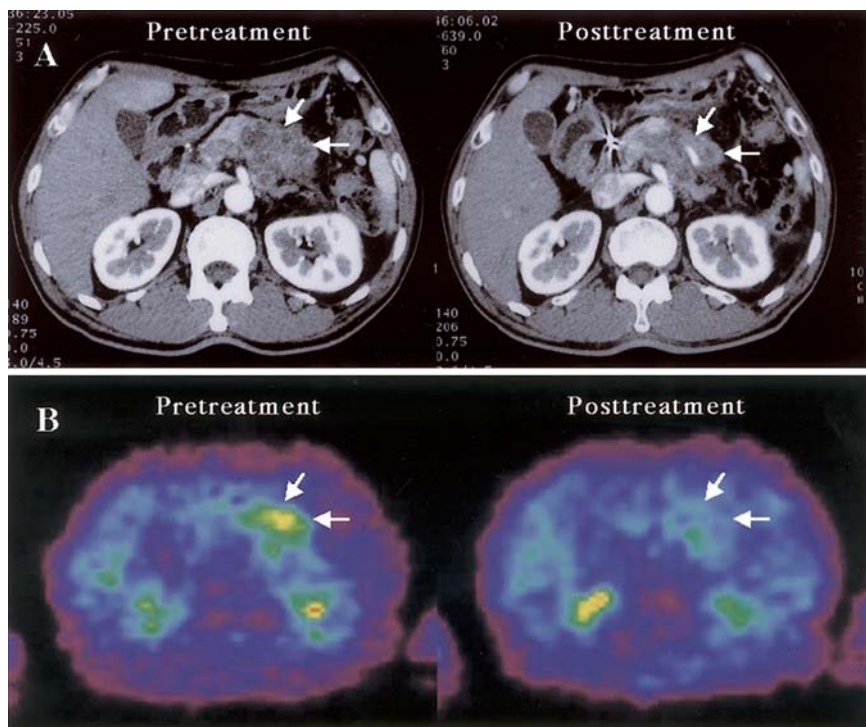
Diagnostic images of patient 1, as a representative of category I. A The size of the tumor in the pancreatic body (*arrows*) is visibly reduced in the post-treatment stage. B Pretreatment 2-deoxy-2-[^{18}F]fluoro-D-glucose positron emission tomography (FDG-PET) image shows increased FDG uptake in the pancreatic body (*arrows*); the uptake is clearly reduced in the posttreatment stage
